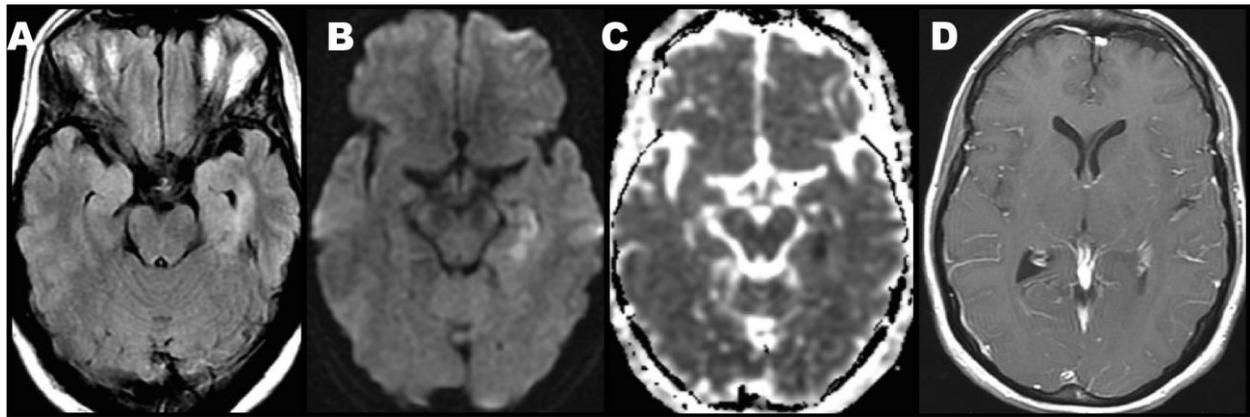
MRI brain on presentation: Axial T2 FLAIR (A) showing bilateral medial temporal hyperintensities, greater on the left with restricted diffusion of the left hippocampus (B and C). T1 post-contrast image shows no evidence of meningeal or parenchymal pathology.
